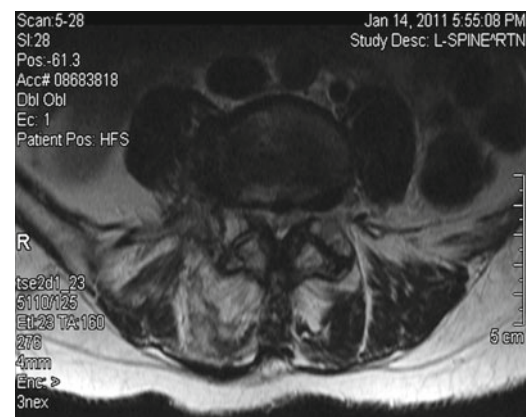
Axial T2 MRI demonstrating spinal stenosis
